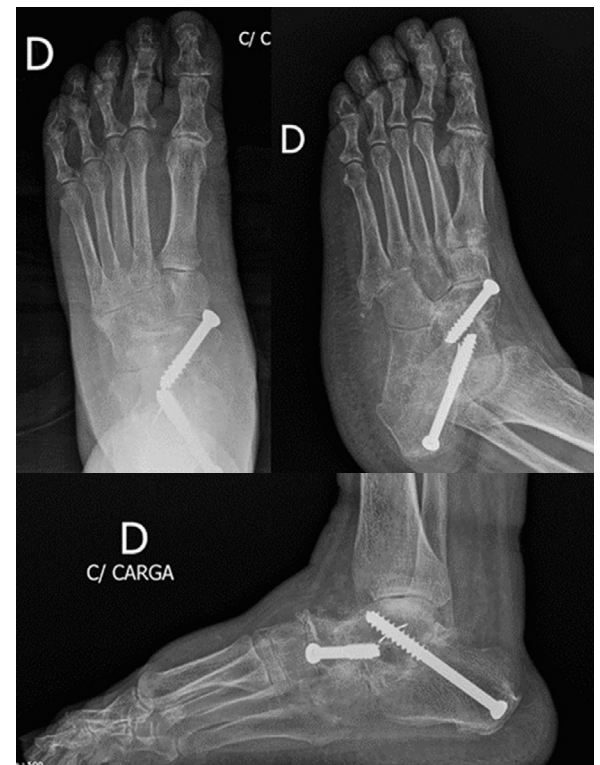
Radiographs of the same patient in Figure 1 showing the procedure used (talonavicular and subtalar arthrodesis with screws).
